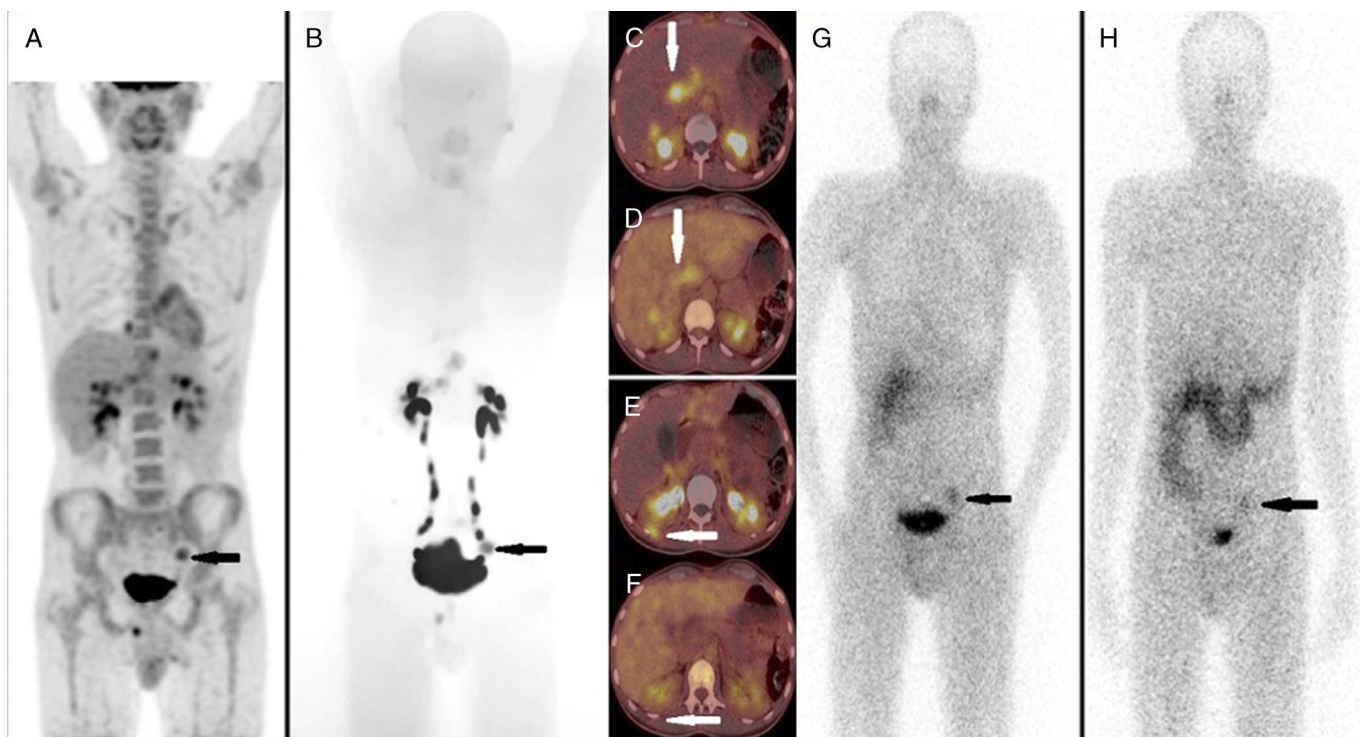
A 28-year-old man with desmoplastic small round cell tumor with prior history of abdominal surgery and chemotherapy underwent ^{18}F -FDG PET/CT and ^{68}Ga -FAPI PET/CT. ^{18}F -FDG revealed FDG-avid metastases in the right paracardiac lymph node, several abdominal, and pelvic lesions, liver, and right hemiscrotum (A). ^{68}Ga -FAPI PET/CT revealed almost the same FAP-avid lesions observed in ^{18}F -FDG (B). The SUV_{max} of the lesions on ^{68}Ga -FAPI PET/CT (white arrows) (C) were higher in intensity rather than on FDG PET/CT (white arrows) (D), and also 1 lesion in the posterior abdomen, which was visualized on ^{68}Ga -FAPI PET/CT (white arrows) (E), did not show any uptake on FDG PET/CT (white arrows) (F). In contrary, the lesion in the mediastinum had higher resolution on FDG PET/CT rather than ^{68}Ga -FAPI PET/CT. The patient underwent 2 cycles of PTRT (6.6 GBq). Posttherapy scintigraphy after the first cycle (G) showed radiotracer uptake in lesions. According to the posttherapy scintigraphy of the second cycle (H), a decrease in uptake of the left pelvic lymph node involvement (dark arrows) was observed, but the patient was considered stable in total.
